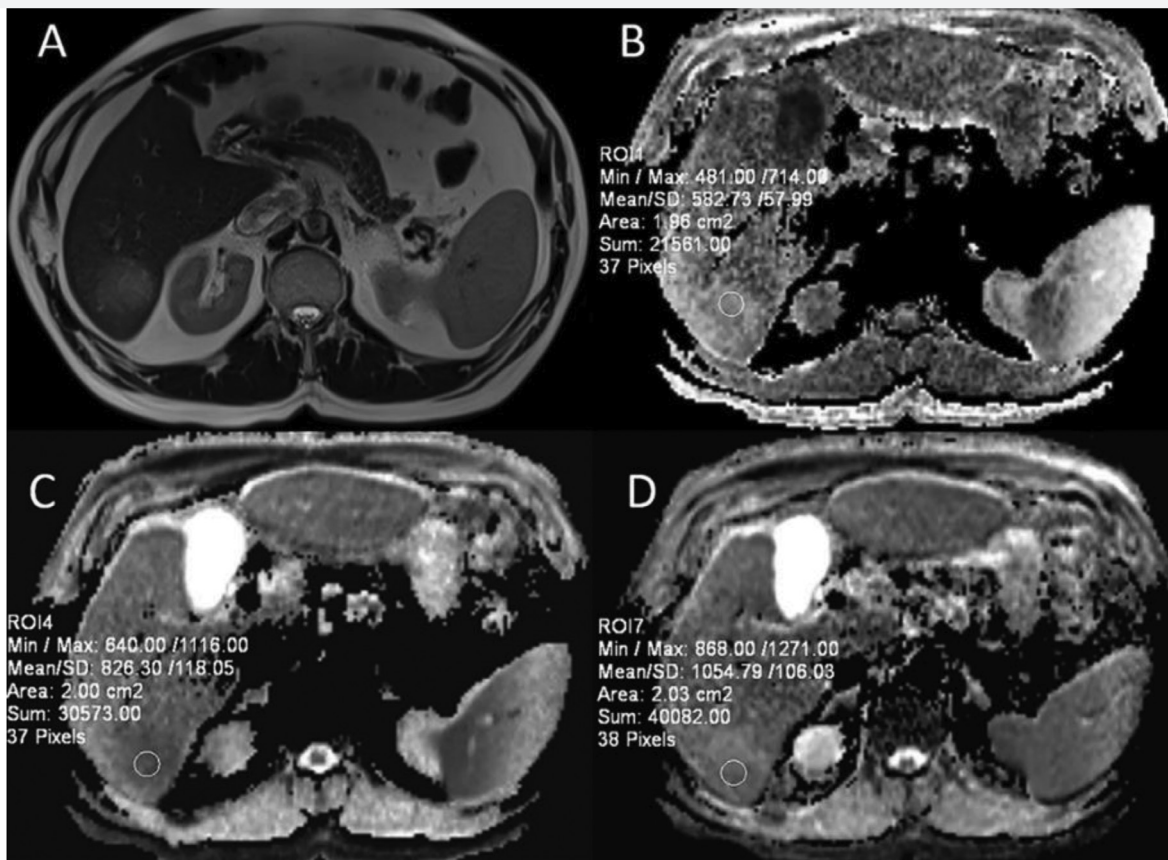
MRI images of a 60-year-old man with biopsy-proven hepatocellular carcinoma
